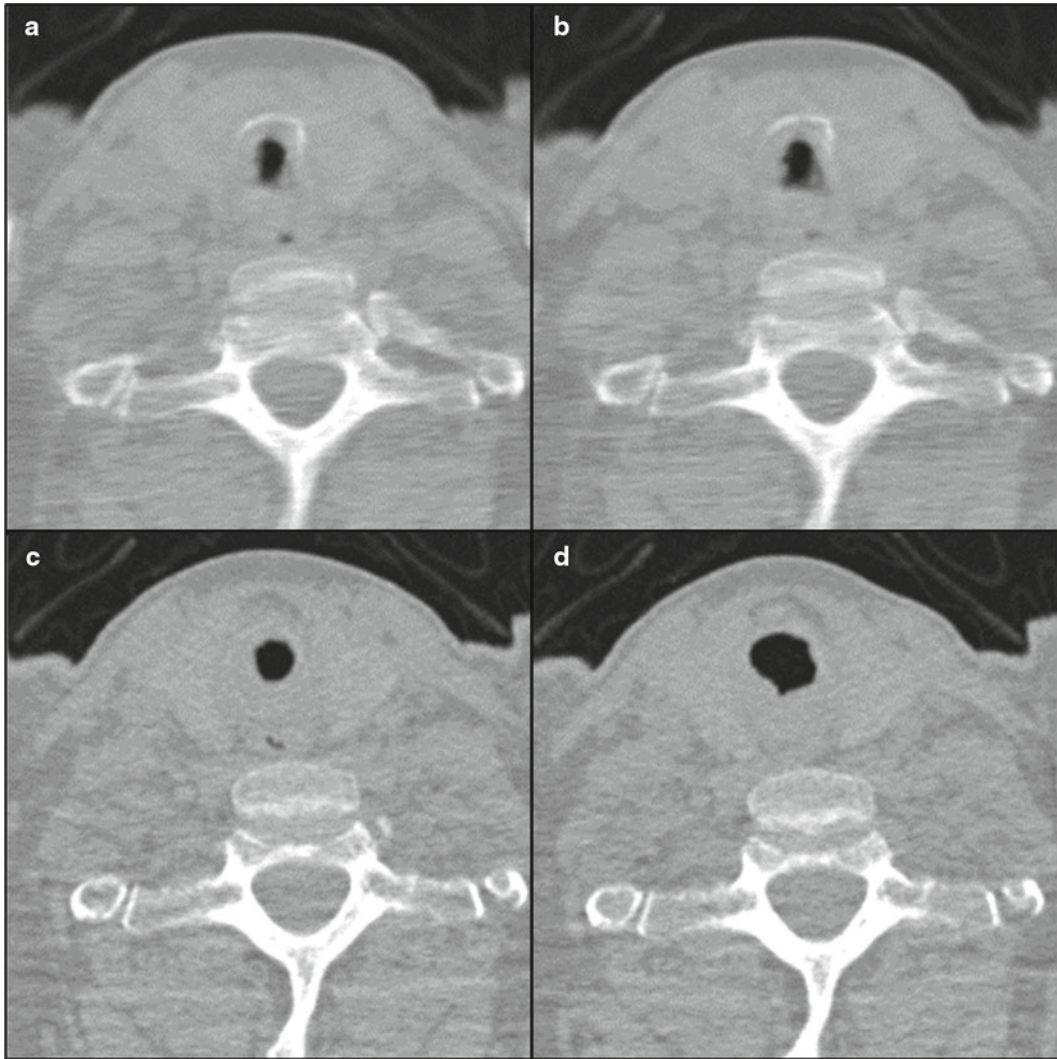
(a) inspiratory breath hold, (b) expiratory breath hold, (c) maximal lumen in cine-CT, (d) expiratory breath hold. The 67-year-old patient was tracheotomized after substitution of mitral valve due to post-operative complications including seizure and pneumonia 2 months ago.
